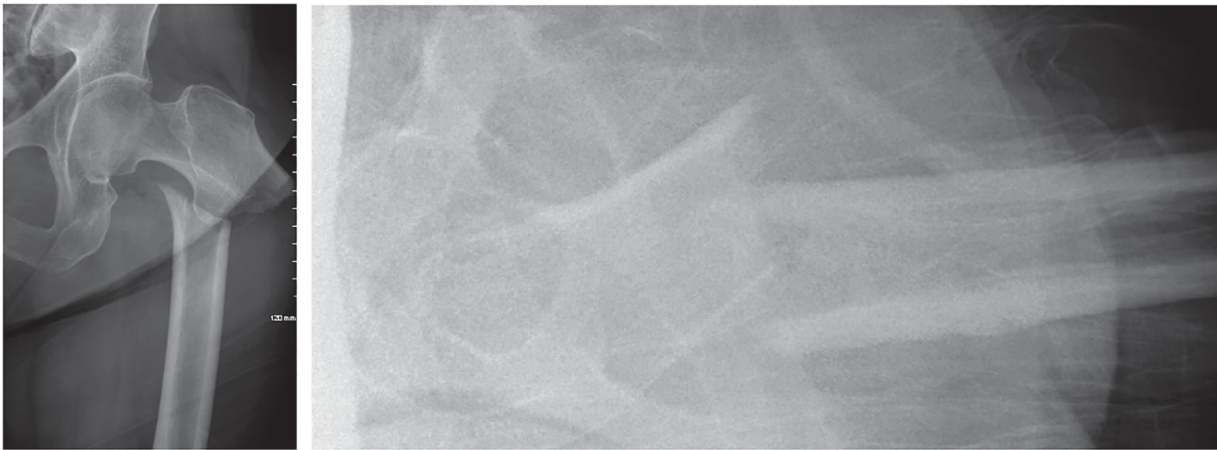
AP and lateral x-ray of a proximal femur fracture. This is an OTA 31A3.1 type femur fracture with typical noted deformity.
